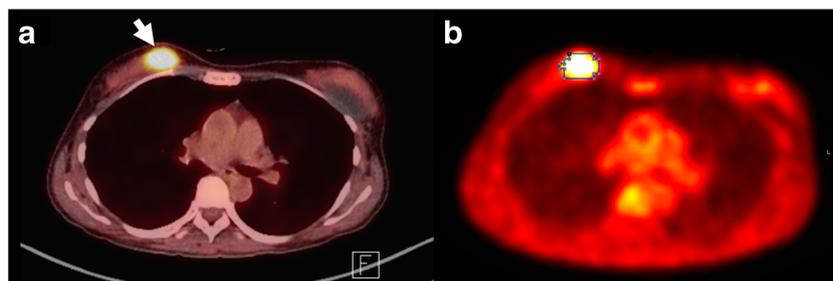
ER-positive/HER2-negative invasive ductal carcinoma in a 45-year-old woman. The pathologic invasive tumor size was 3.0 cm without lymph node metastasis (pT2N0). The nuclear grade was 2, and the IHC expression profiles were ER 70 %, PR 96 %, HER2 score 2+, and Ki-67 4 %. a The preoperative ^{18}F -FDG PET/CT image shows high ^{18}F -FDG
